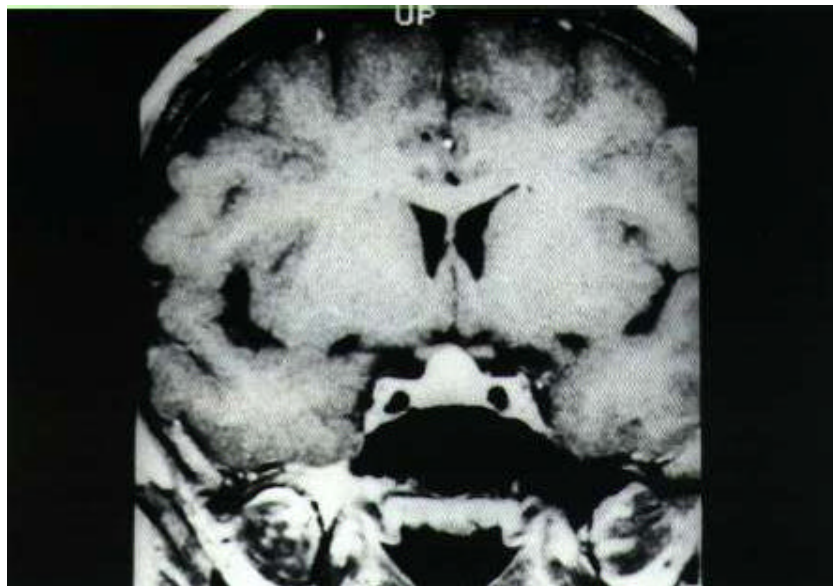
MRI image (coronal view) of case 3.
